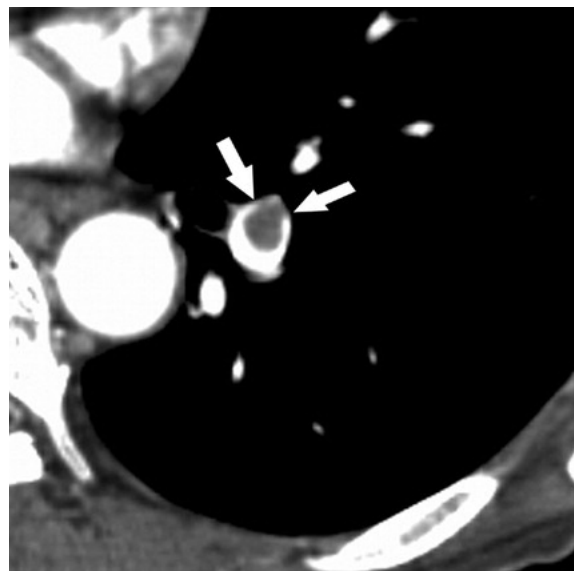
CT with PE presented on the Right Side of the Image, Left Side of the patient.
